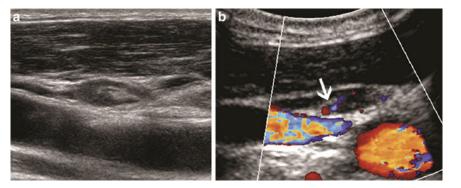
Ultrasound features of normal cervical lymph nodes. (a) Normal fusiform lymph node with hyperechoic hilum. (b) Central, hilar blood flow in a normal lymph
